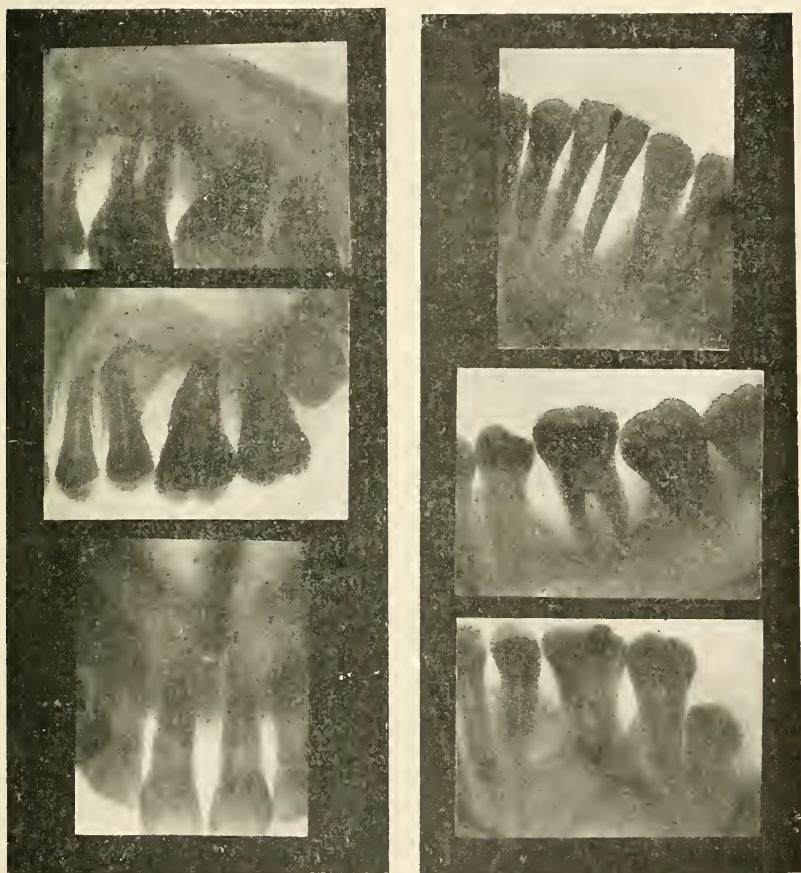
RADIOGRAPHS OF DR. MERRITT'S CASE.
